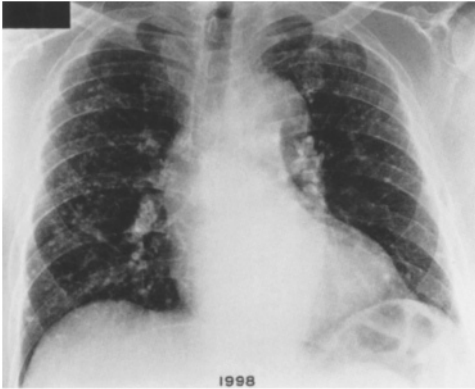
A PA chest radiograph reveals multiple small rounded opacities involving all lung zones bilaterally. These nodules are clearly defined. Note that there are eggshell calcifications in both hilar lymph nodes. According to the ILO classification, this radiograph is read as 2/2 q/q and es
